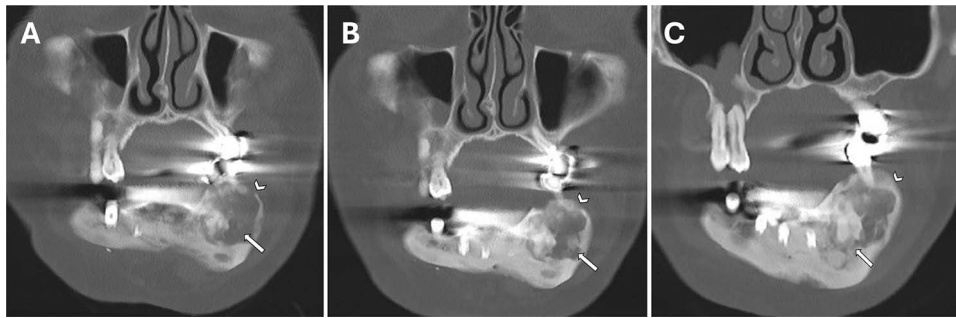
Coronal CT in bone windows through the mandible at the level of the giant cell tumor. (A) Prior to denosumab commencement: A large lytic lesion with endosteal scalloping (arrow) involving the mandibular dental roots and a focal region of cortical demineralization (arrowhead). (B) Six months after denosumab commencement: Progressive infilling of the tumor with osteoid post treatment (arrow) and cortical new bone formation and thickening (arrowhead). (C) Thirty months after denosumab commencement: Further progressive tumor osteoid formation (arrow) and healed buccal surface cortical defect (arrowhead).
